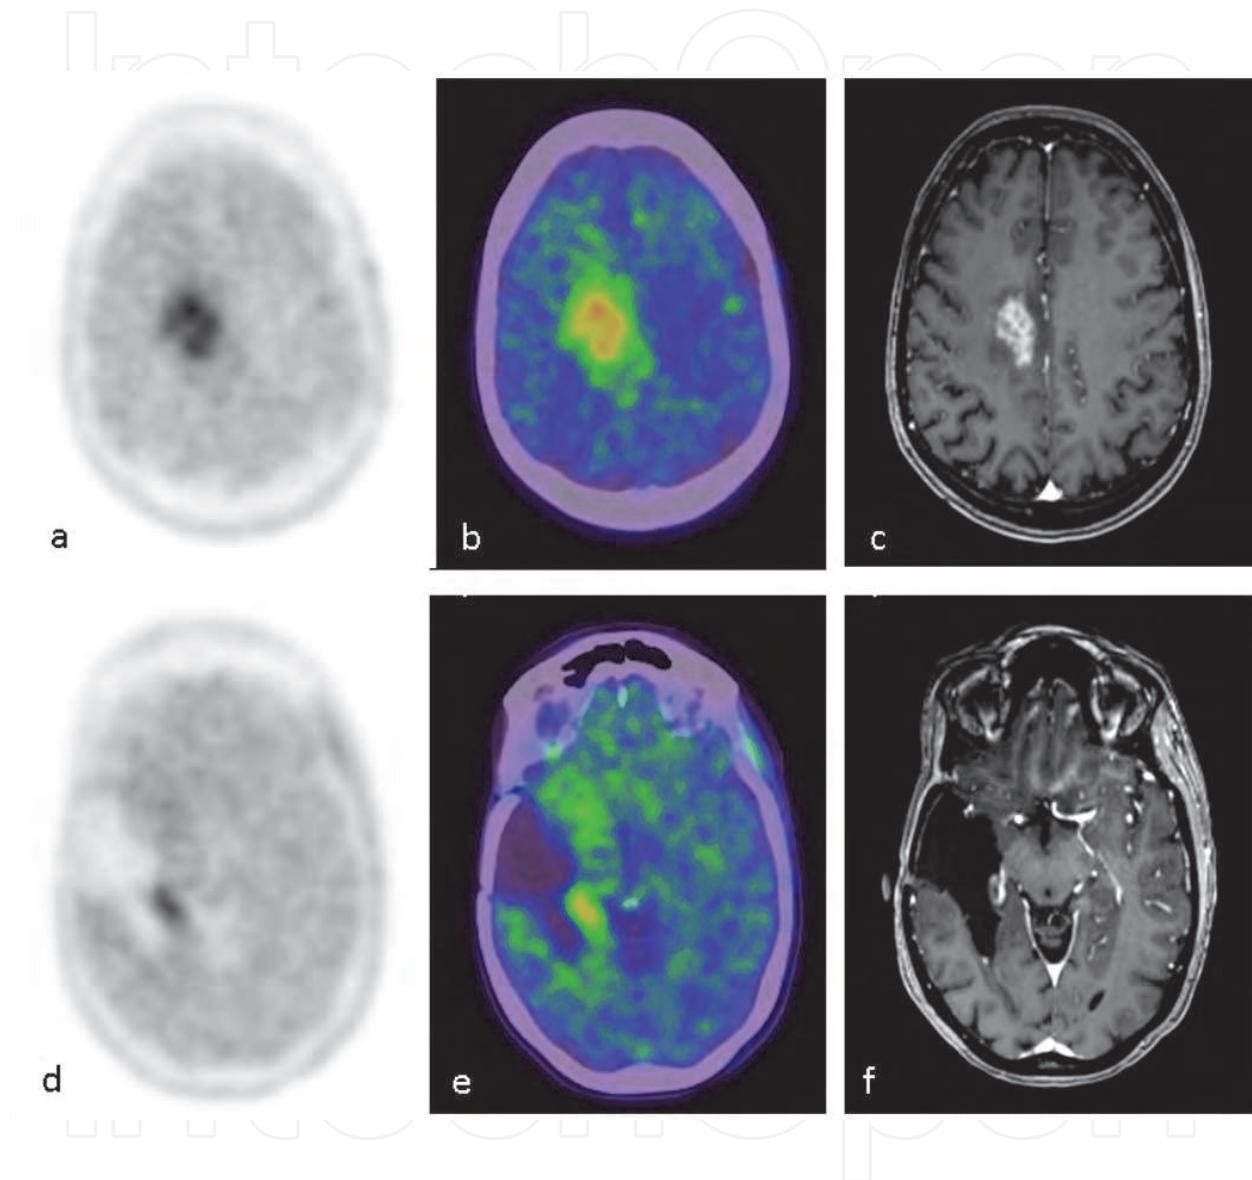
Patient with a recurrent locoregional brain lesion – images show tumour before and after neurosurgery and radio-chemotherapy. a, d) FET-PET image showing intense uptake in the tumour tissue before and recurrent tumour after neurosurgery; b, e) Fused PET-CT image confirming the location of the tumour and recurrent lesion before and after surgery; c, f) post contrast MRI image in concordance to strong FET-tracer uptake shown in PET/CT. Furthermore, an additional brain lesion was identified in the right parietal lobe medial area of the brain tissue resected area, presenting a high FET-tracer uptake in PET/CT and strong contrast enhancement in MRI.
